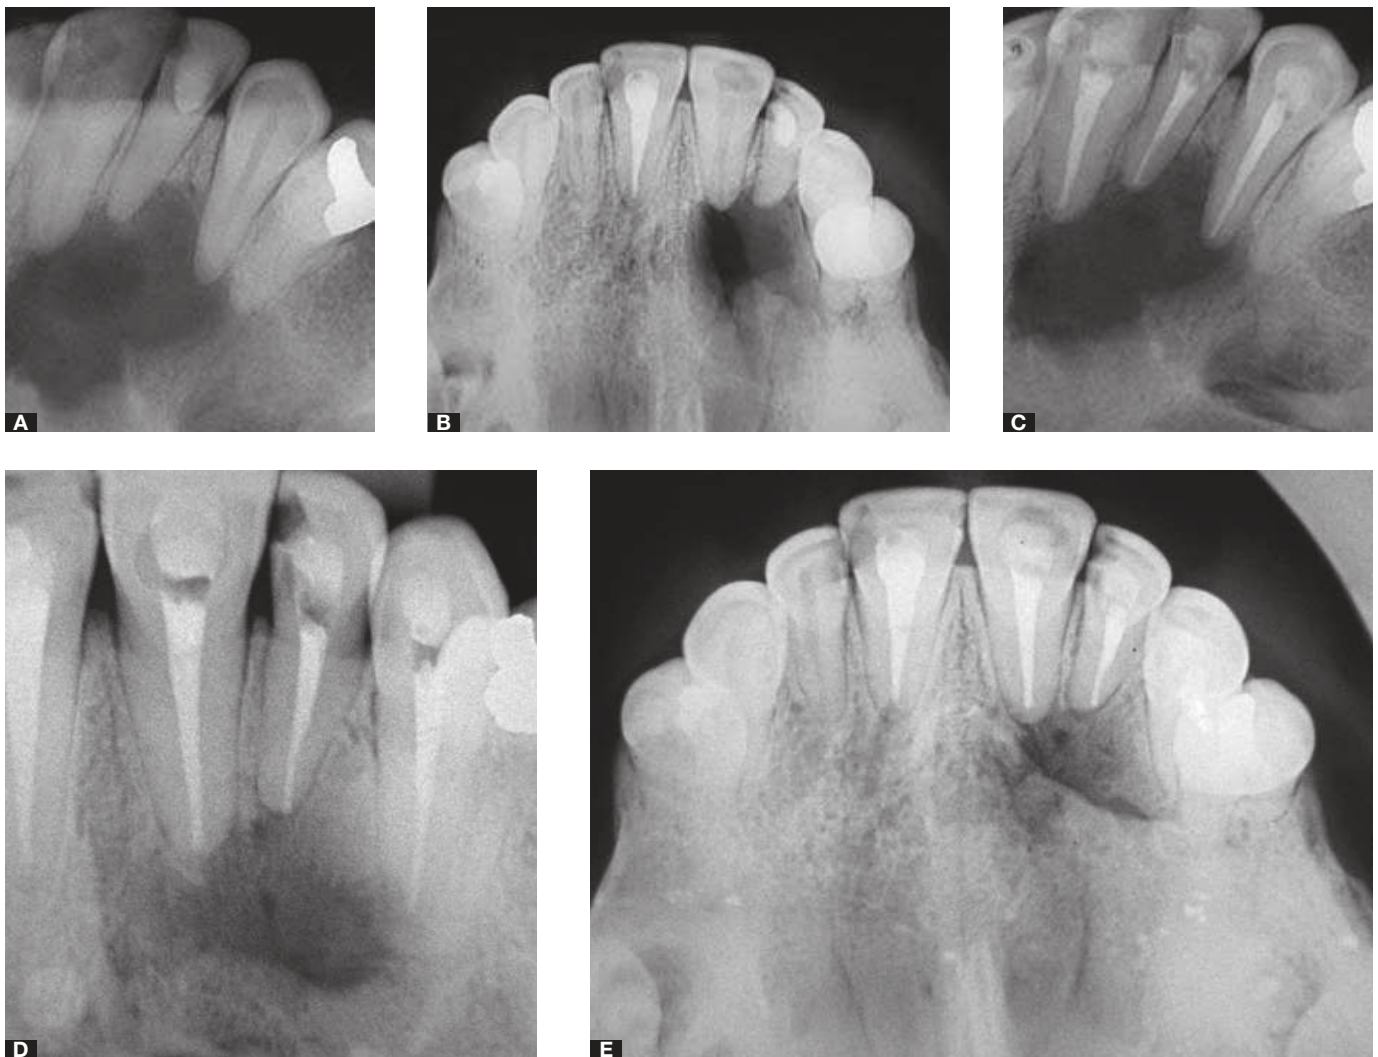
A) Pre-operative radiograph. Presence of severe maxillary bone resorption. Patient presented swelling and pain. B) Occlusal radiograph. C) Pre-operative radiograph after root canal treatment. Absence of healing can be noticed. D) Six month review radiograph. A satisfactory healing can be appreciated. E) Six month review occlusal radiograph.
